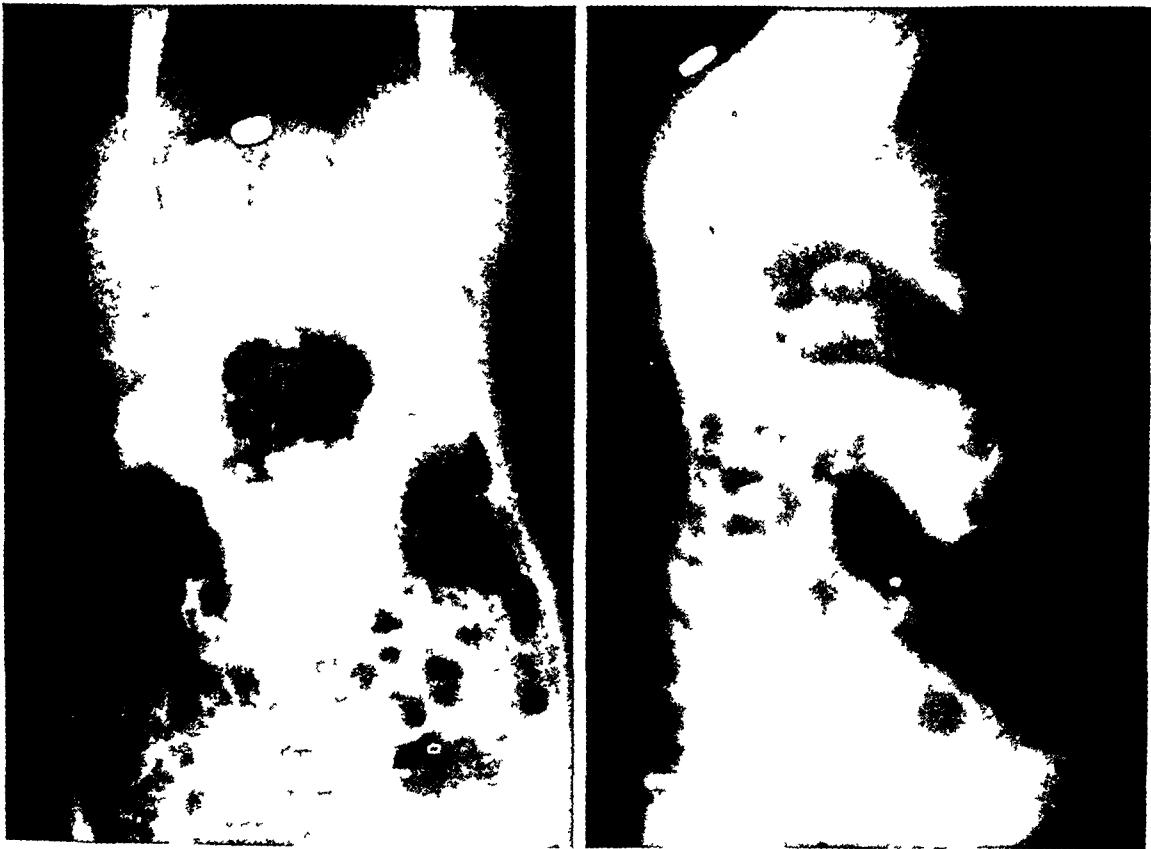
Anteroposterior and lateral roentgenograms of J D (Case 2) before operation obtained by the method of Wangenstein and Rice ⁶
